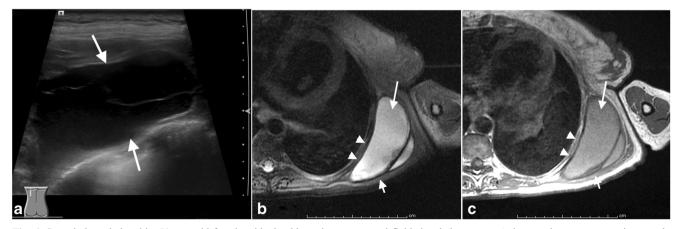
Scapulothoracic bursitis. 51-year-old female with shoulder pain and a palpable abnormality. a Longitudinal ultrasound image shows anechoic fluid superficial to the chest wall and deep to the superficial musculature. b axial T2 FSE and c axial T1 images show shows hyperintense
